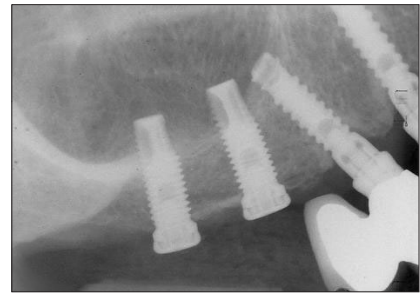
Final periapical radiograph before restorative treatment was initiated.
